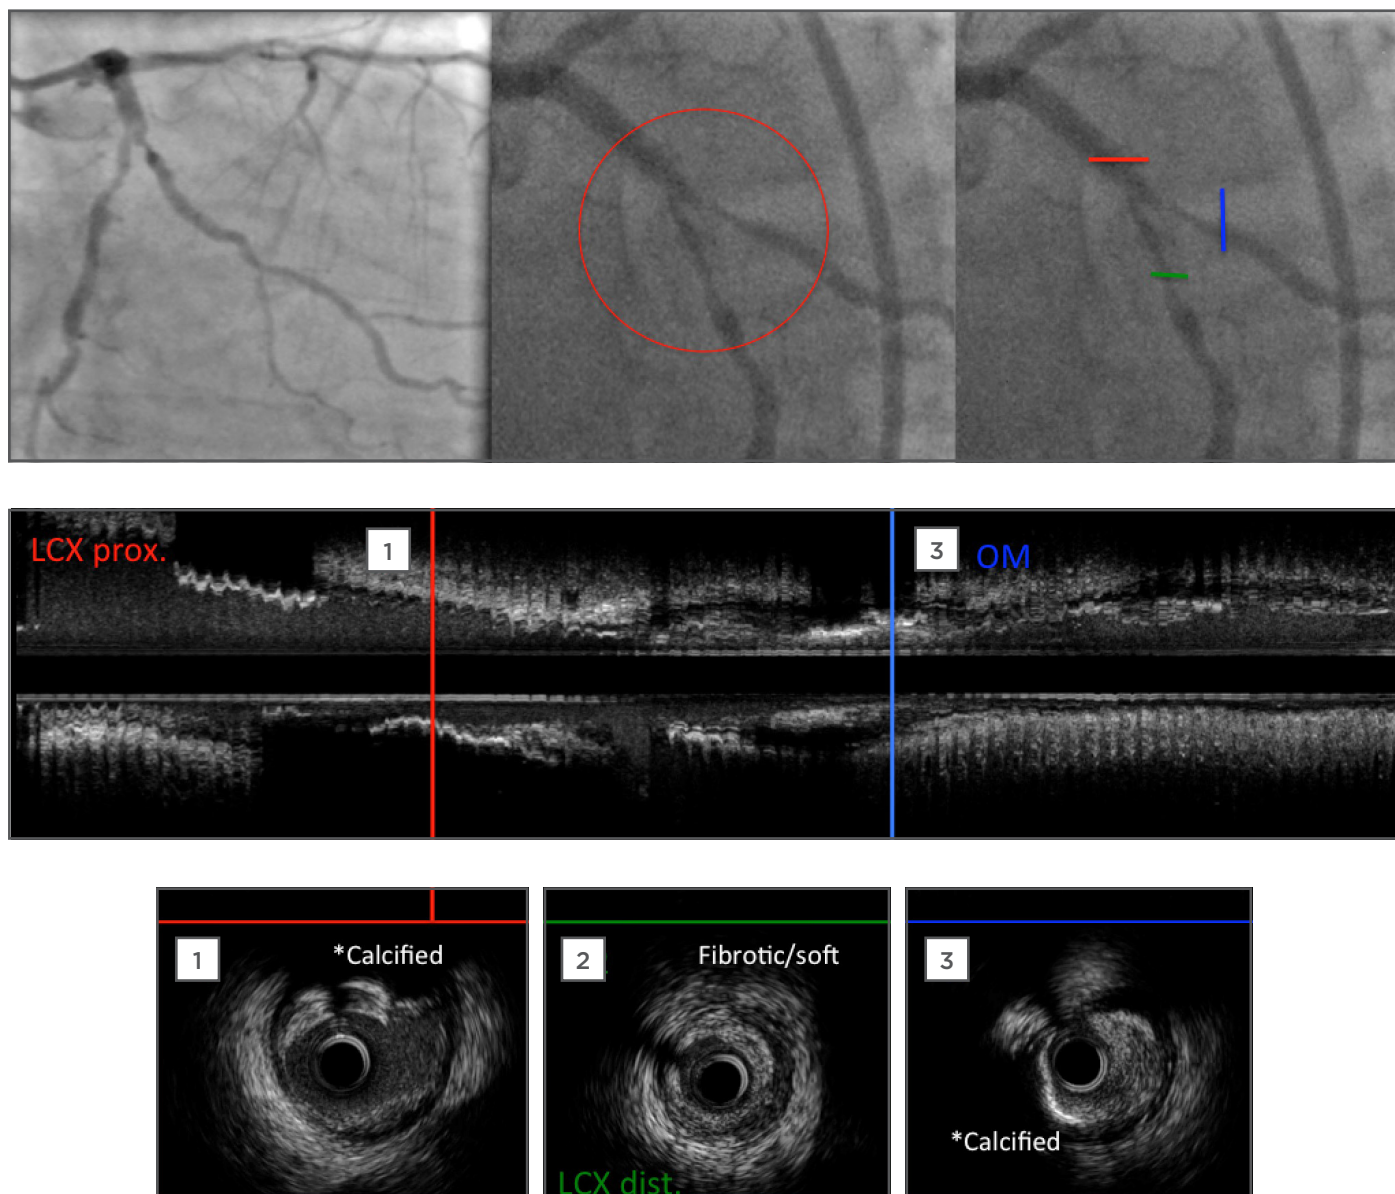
Pre-percutaneous coronary intervention angiographic images and intravascular ultrasound (IVUS) pullback.
